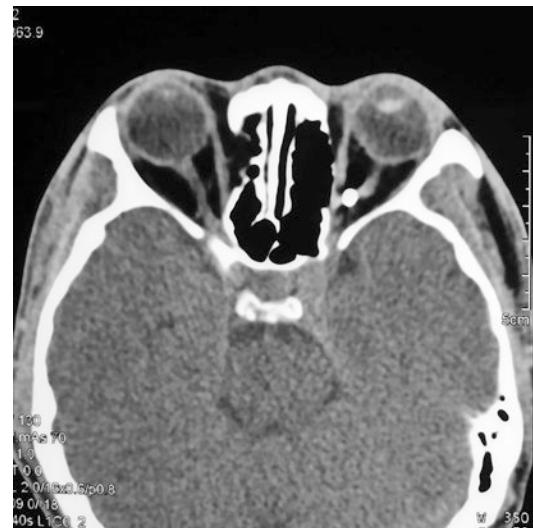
Preoperative axial computed tomography (CT) scan revealing a metallic foreign body located in deep orbit muscles cones
